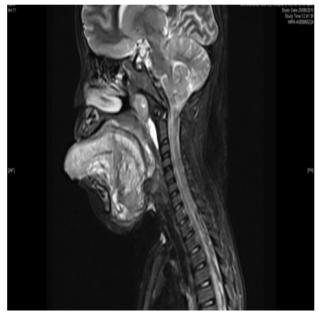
MRI saggital view showed the hemolymphatic malformation and diffused hemangiomatous involvement at the base the tongue and pushed tongue anteriorly
